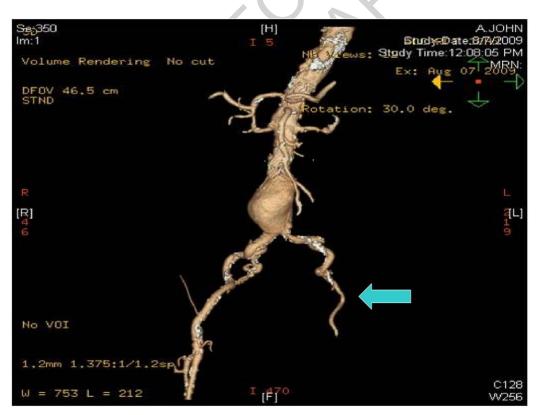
CTA with 3-dimensional reconstruction (arrow indicating occlusive disease at left iliac artery).
